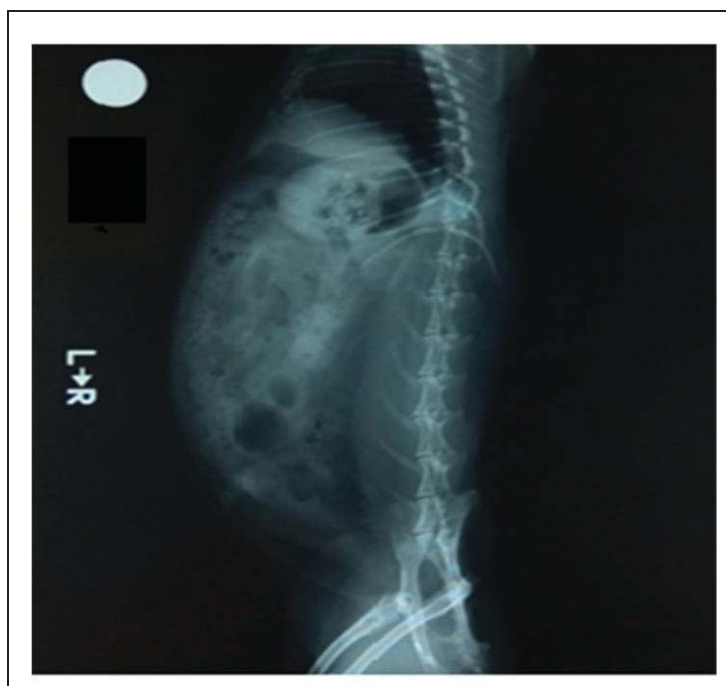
X-ray imaging radiograph at 0 hours
